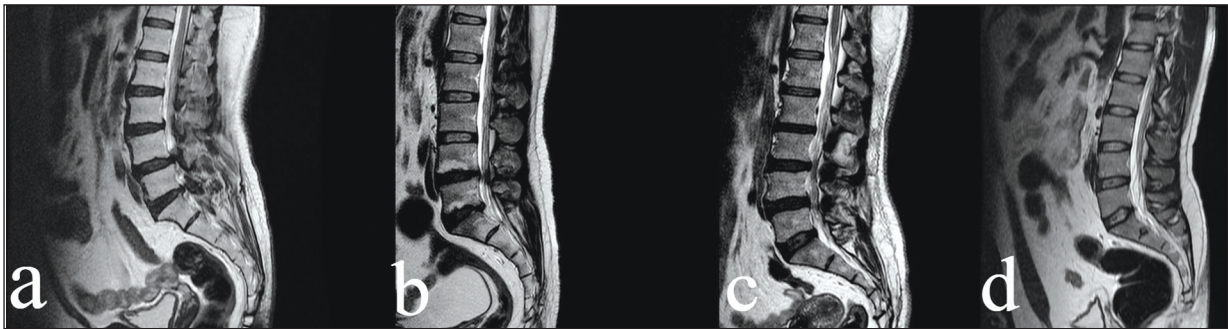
Sagittal T2-weighted MRIs, CFSLS score is 0 at L4-5 level (a) CFSLS score is 1 at L4-5 level (b), CFSLS score is 2 at L4-5 level (c) and CFSLS score is 3 at L4-5 level (d).
